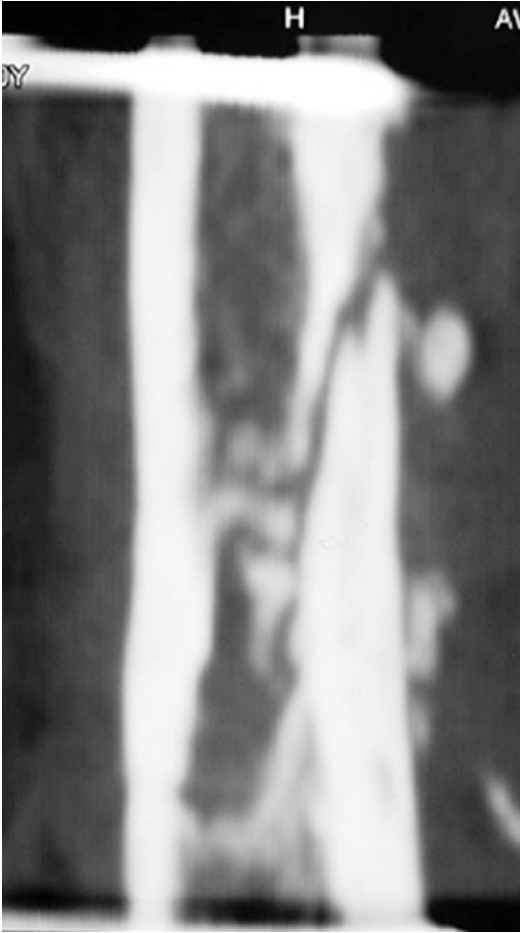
A CT scan of the femur, confirming a subtle nonunion
